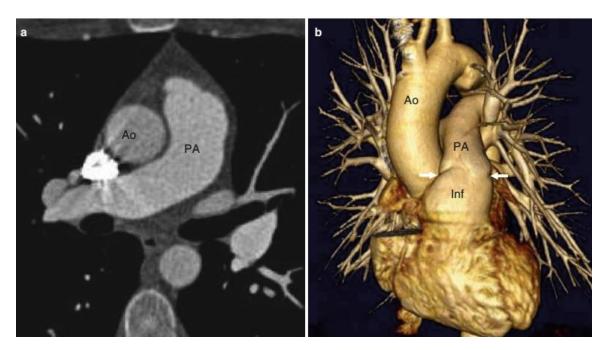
Panel (a) is an axial, maximum-intensity projection, CT image demonstrating the normal spatial orientation of the great vessels. The PA is to the left of the aorta. Panel (b) is a 3-dimensional volume rendered CT image showing the aorta posterior and to the right of the pulmonary artery. Which is designated as situs Solitus of great vessels "{_, _, S}".
